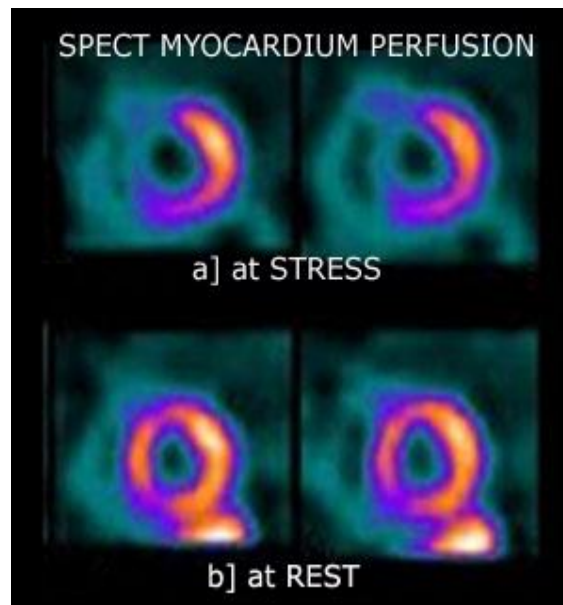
Two sets (stress-rest) of SPECT slices.
